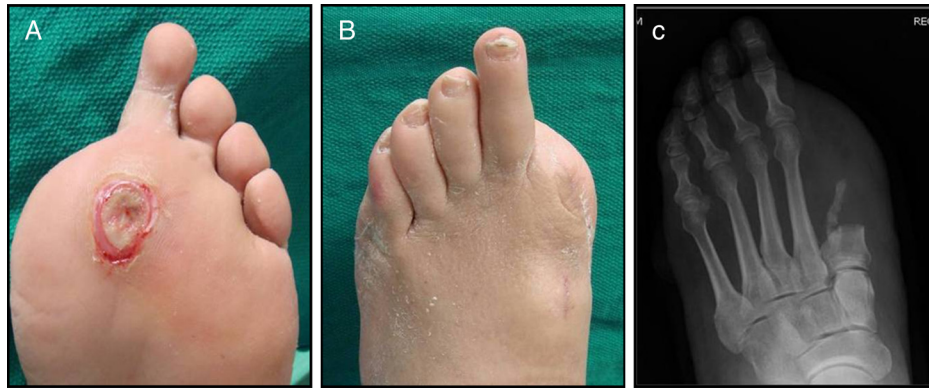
(A–C) Preoperative photographs and radiograph depicting patient 1 with recurrent and worsening second metatarsal phalangeal joint transfer ulcer with a history of first ray amputation. Surgery was delayed until the dorsal cellulitis had resolved, although a 2-stage approach has been commonly used for deep infection. Note, the patient had minimal lesser toe deformity, healthy digital skin, and no evidence of osteomyelitis in the second proximal phalanx. Deep wound probing identified bone exposure. Because of these findings, revision surgery involved plantar rotational flap panmetatarsal head resection.
